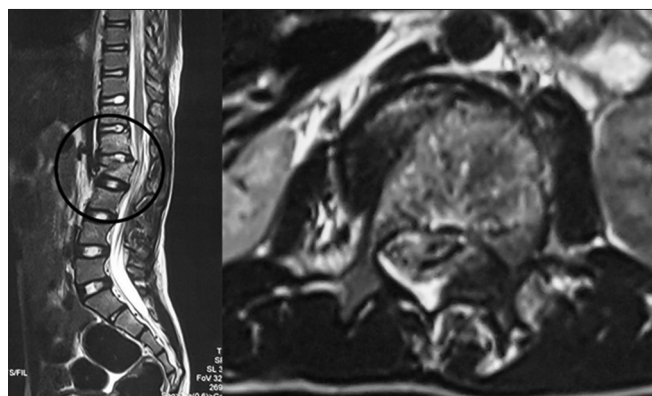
T2-weighted magnetic resonance imaging sagittal and axial views showing mild thecal indentation with mild canal narrowing
